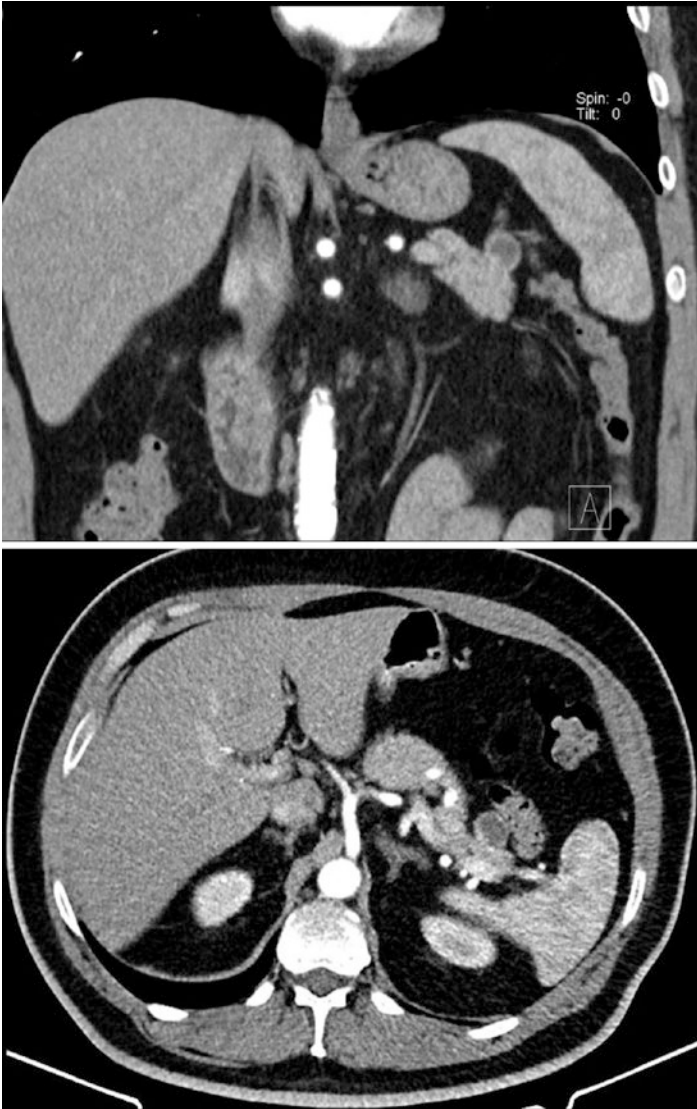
CT scan of a patient with a small cystic NF-pNET in the pancreatic tail
